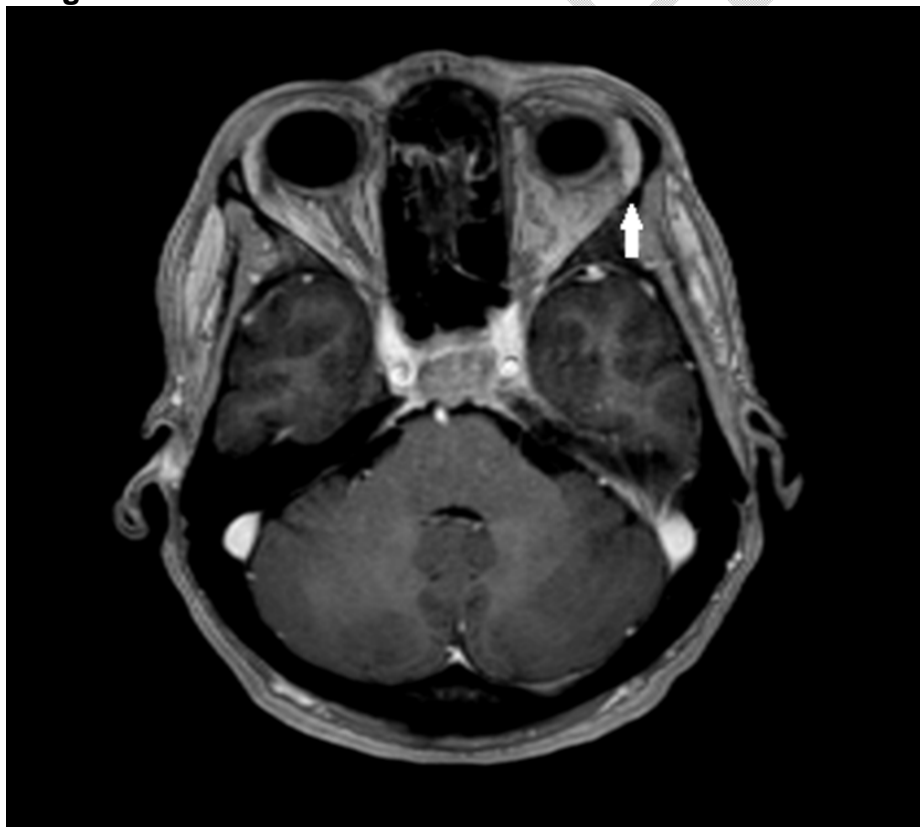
A cerebral CT scan showed a hypodense lesion infiltrating the left orbit in favor of an orbital metastasis (arrow).
